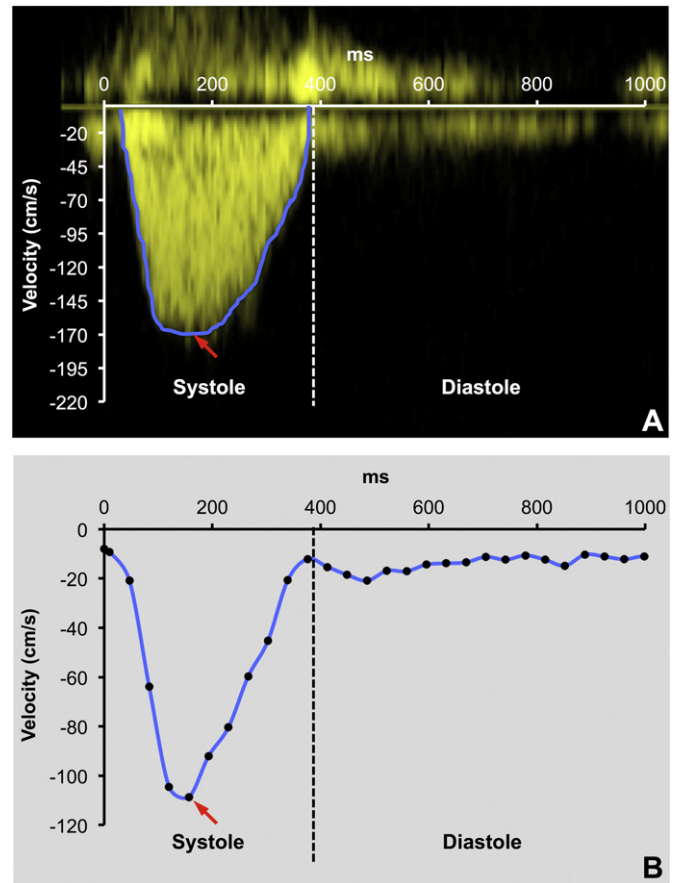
Peak velocity versus time curves. Peak velocity versus time curves for (A) Doppler echocardiography and (B) phase-contrast magnetic resonance (PC-MR) acquisitions were used to identify the peak flow velocity (red arrow) and to calculate the mean flow velocity (time averaged peak flow velocity).
